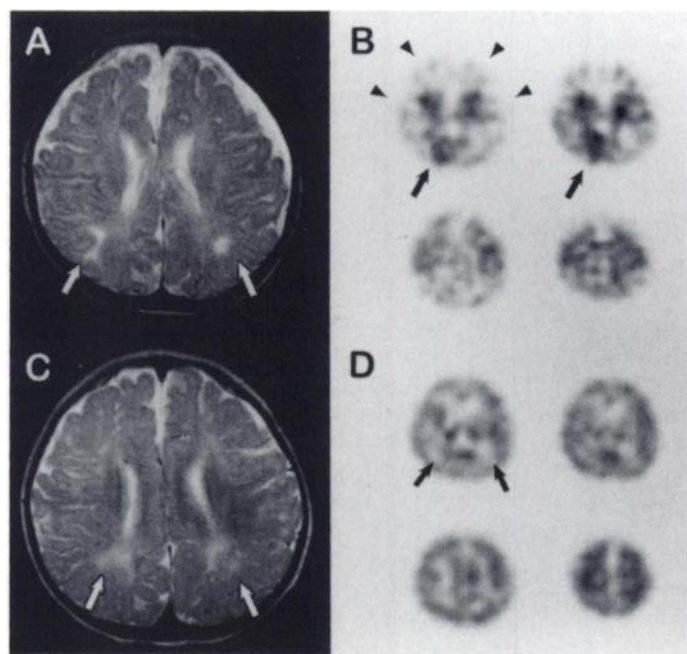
Patient 2. (A) Initial T2-weighted axial MR image shows abnormal high signal intensity (arrows) in white matter of bilateral parietal lobes. (B) Technetium-99m-HMPAO SPECT image reveals relative hypoperfusion in frontal and parietal areas (arrowheads). Hyperperfused area in the right occipital area (arrows) is seen also. (C) Follow-up T2-weighted MR image shows partial resolution of parietal lesions (arrows). (D) Technetium-99m-HMPAO SPECT image reveals mild white matter hypoperfusion (arrows).
